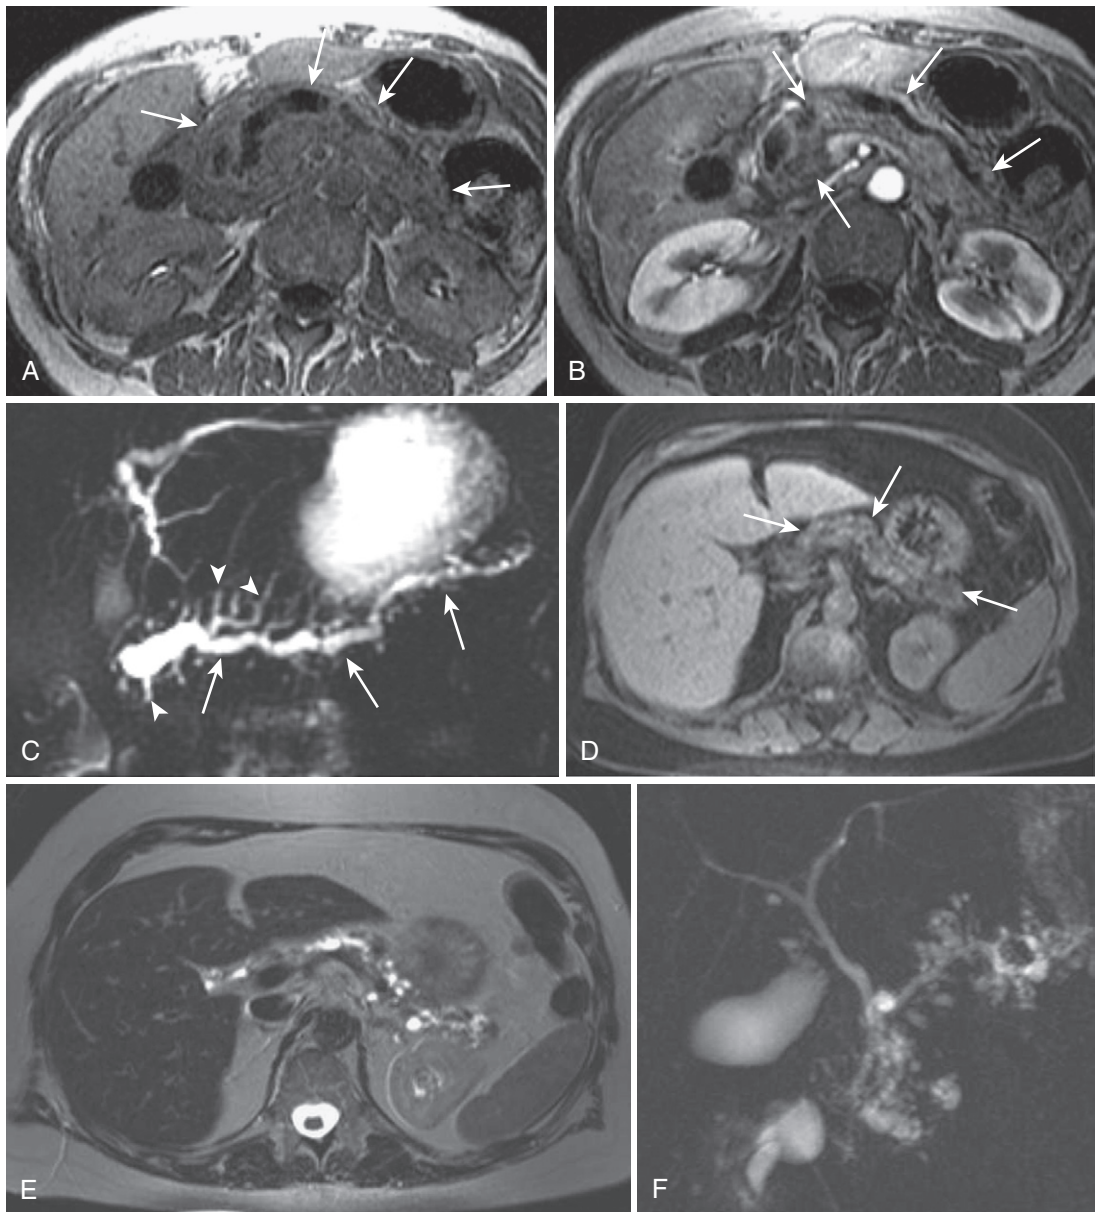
Chronic pancreatitis. A, The in-phase (T1-weighted) image through a chronically inflamed pancreas (*arrows*) reveals relative parenchymal hypointensity and irregular beaded ductal dilatation. B, The early phase postcontrast image shows the extent of ductal dilatation (*arrows*) in the pancreatic body and heterogeneously decreased enhancement. C, The MRCP image isolates the pancreatic duct (*arrows*) from the parenchyma and surrounding tissues, depicting the irregular pancreatic ductal and side branch dilatation (*arrowheads*). D, The T1-weighted fat-suppressed image in a different patient with chronic pancreatitis exemplifies the typical heterogeneous decrease in parenchymal signal intensity (*arrows*). The heavily T2-weighted (E) and MRCP (F) images show the associated ductal changes, typifying the “chain of lakes” or “string of pearls” appearance.
